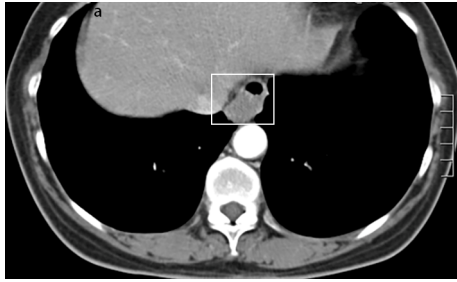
Computerized tomography (CT) revealed a 2.1 × 1.9 cm hypoechoic lesion in the lower-esophagus and protruded to the mediastinal without invading the surrounding nerves and blood vessels.
